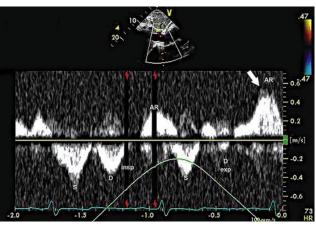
Cardiac tamponade: PW Doppler of the hepatic vein in a patient with cardiac tamponade. S and D are antegrade flow in systole and diastole, respectively, and AR is retrograde flow in diastole. A decrease in the diastolic flow or a large AR particularly during the first beat of expiration are hallmarks of cardiac tamponade. PW Doppler of the hepatic vein should be obtained in all patients with suspected cardiac tamponade if obtainable.
